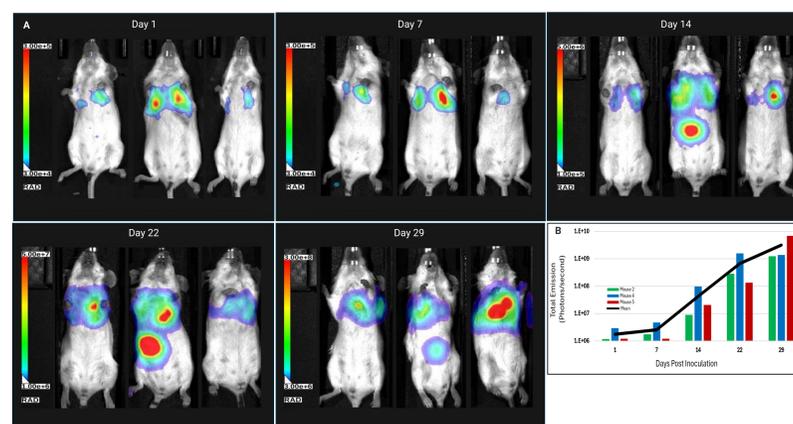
BLI *in vivo* monitoring of CT-26 tumor progression over time.
